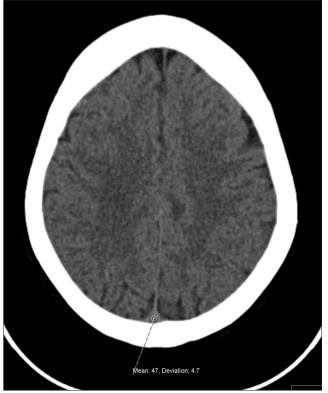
A 39-year-old woman with antiphospholipid syndrome who presented with a headache. (b) A non enhanced CR image in the same control patient shows the ROI plotted on the posterior superior sagittal sinus. The average mean HU value of the three ROIs is 42.33. Contrast-enhanced CT brain (not shown) shows no evidence of venous thrombosis.
